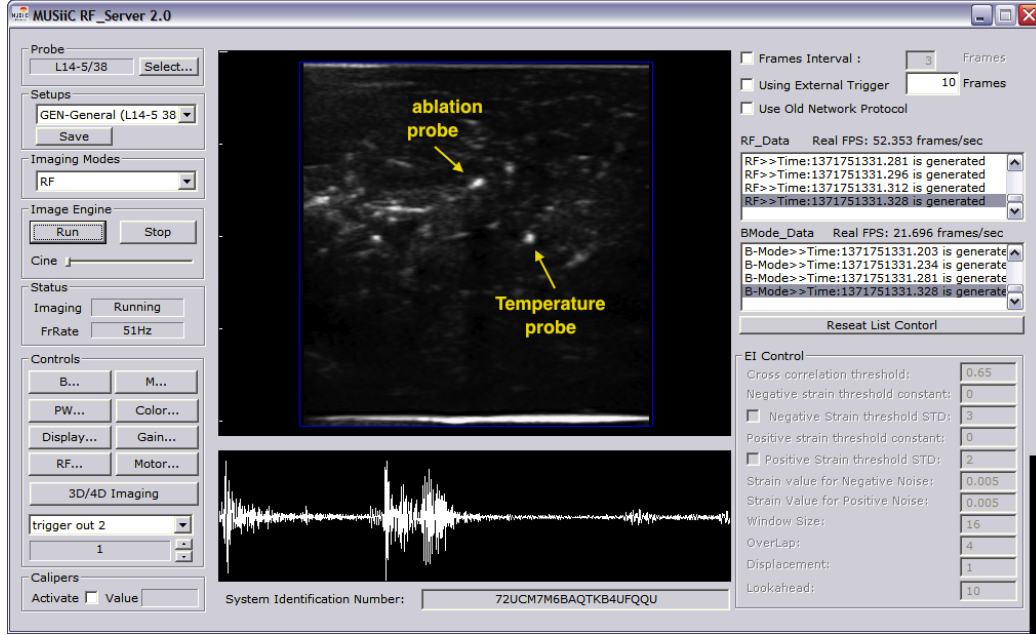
Screen capture of the MUSIIC RF server data acquisition system. Visible on conventional B-mode ultrasound image of the tissue are the ablator probe tip and also the tip of the temperature reading probe.
